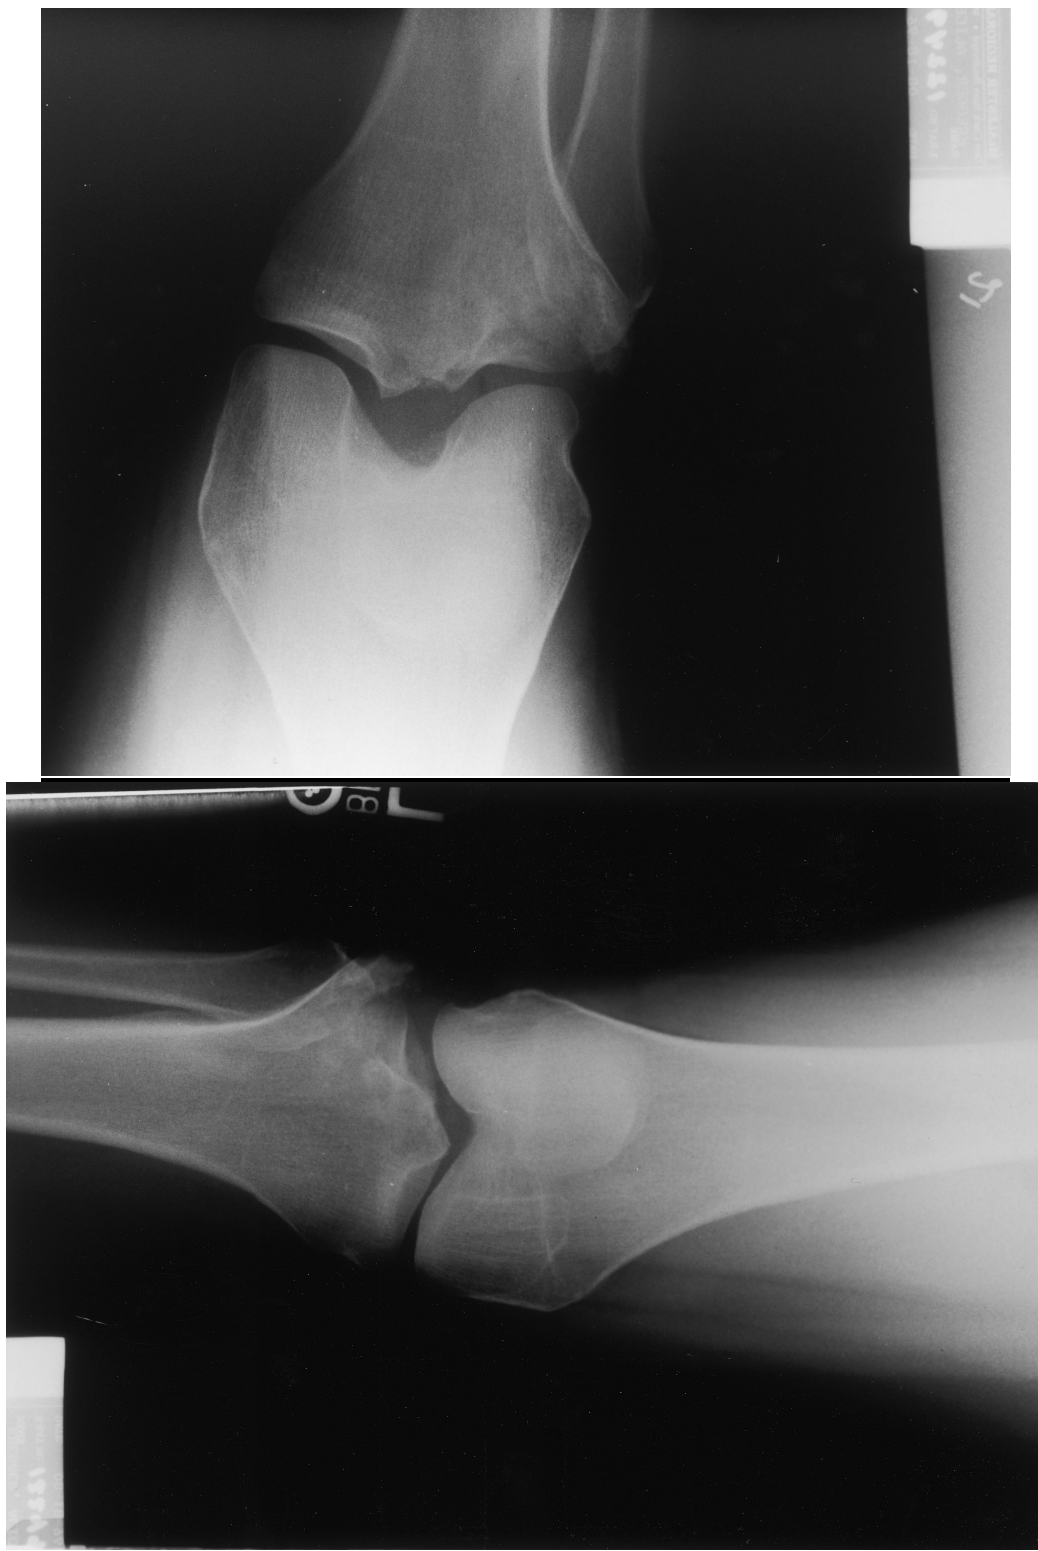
Radiographs from PWC File 7.
